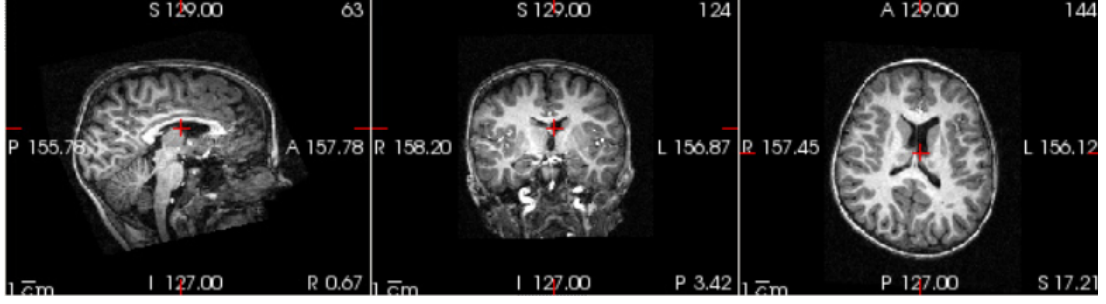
This image depicts a structural magnetic resonance imaging (sMRI) scan of the head, exhibiting intricate anatomical features of the brain as seen in three planes: sagittal, coronal, and axial.
